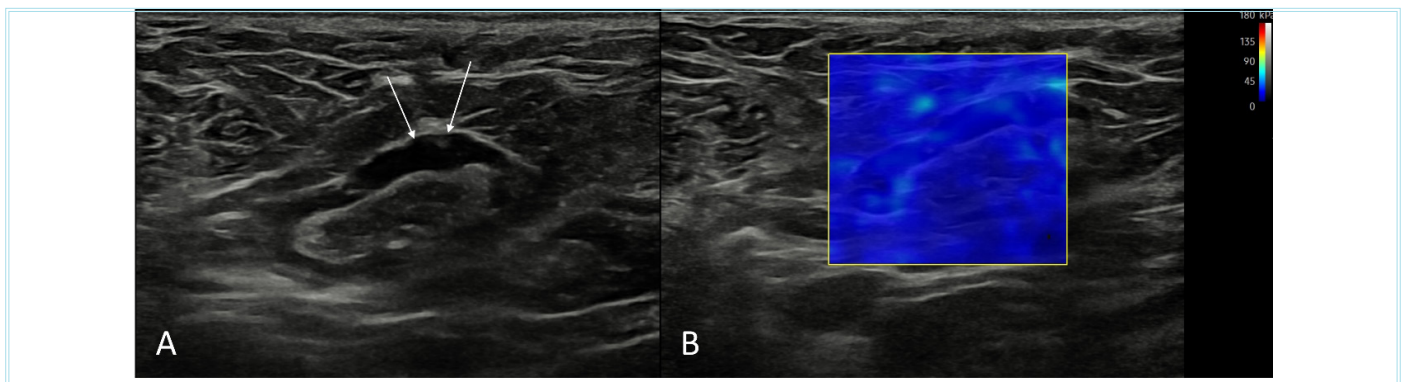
A 57-year-old female patient diagnosed with breast cancer. A) B-Mode ultrasound image of the right axillary lymph node showing focal mild cortical thickening (arrows) is present. B) Shear wave elastography image of the same lymph node showing no color coding indicative of tissue stiffening is observed (rectangle). Core biopsy pathological findings indicated a reactive lymph node. Elastographic measurement values are not numerically presented in this figure
